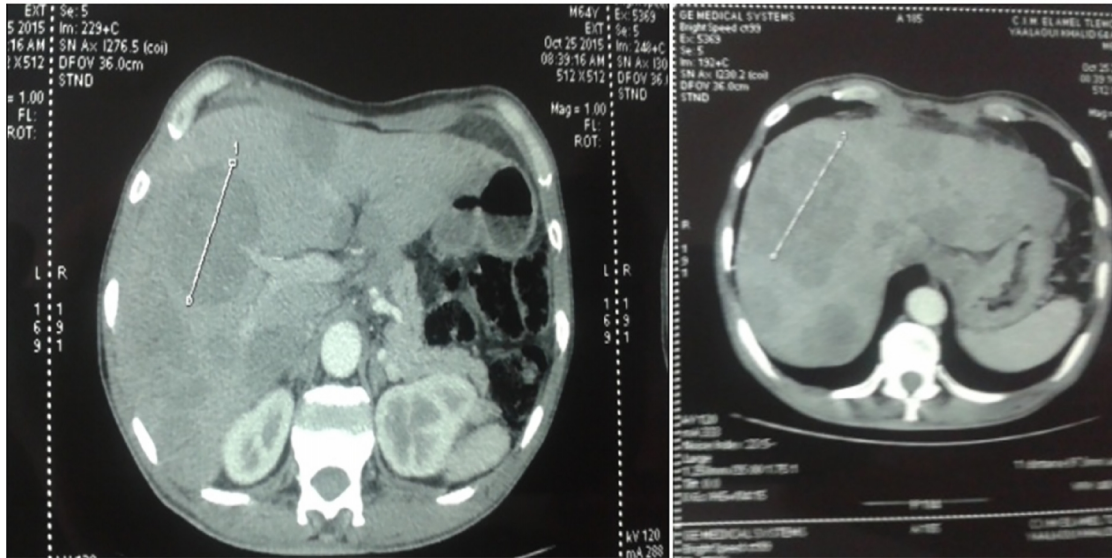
CT scan of the abdomen (A and B) shows multiple variable-sized metastatic nodular lesions in the liver.
